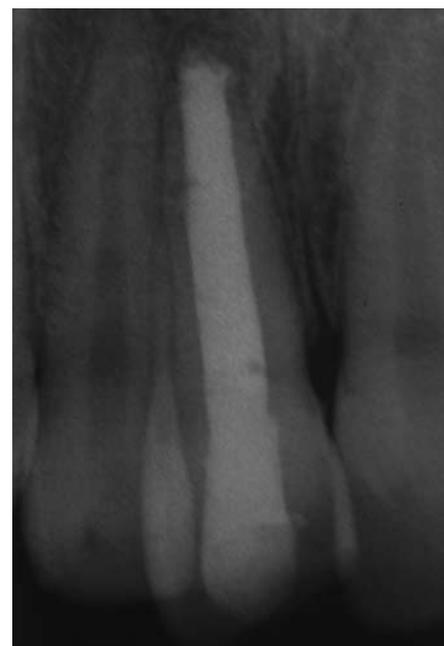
Pre-treatment periapical view of the upper right central incisor.
